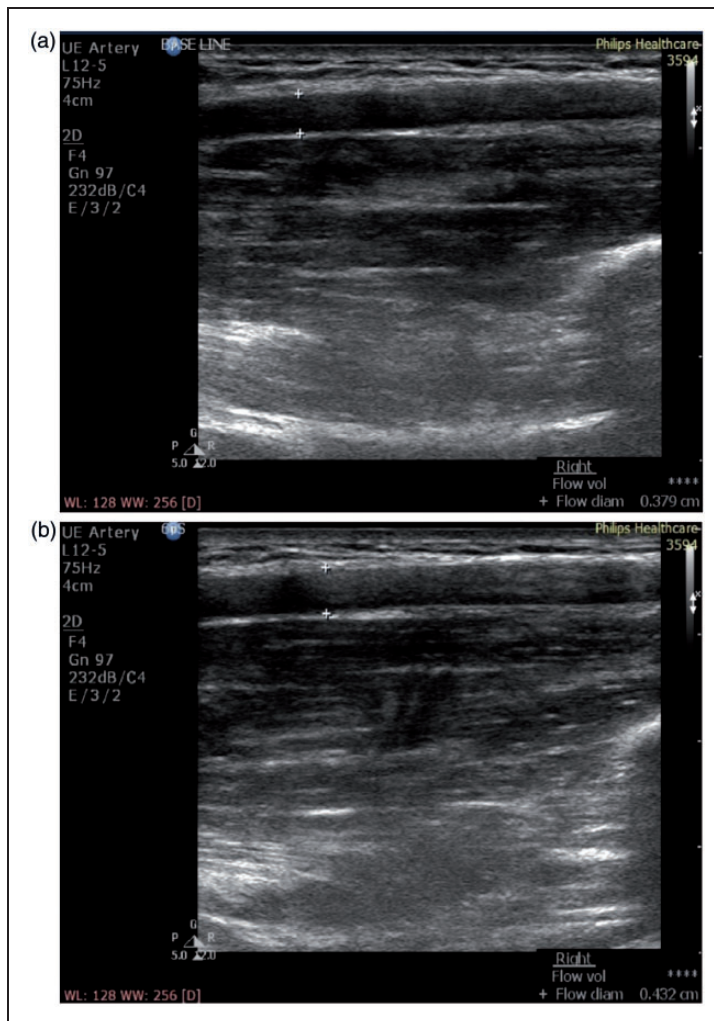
Representative grey-scale sonograms from a healthy Chinese male young adult showing measurement of: (a) baseline diastolic brachial artery diameter, where lumen diameter was defined as the perpendicular distance between the tunica media of the near and far artery wall (shown between the callipers '+'), corresponding to 0.379 cm in the present figure; and (b) reactive diastolic brachial artery diameter (during hyperaemia), obtained 60 s following deflation of a sphygmomanometer cuff at 50 mmHg above the systolic blood pressure of the subject for a duration of 5 min, corresponding to 0.432 cm (shown between the callipers '+'). Thus, brachial artery FMD for this patient was 14%
